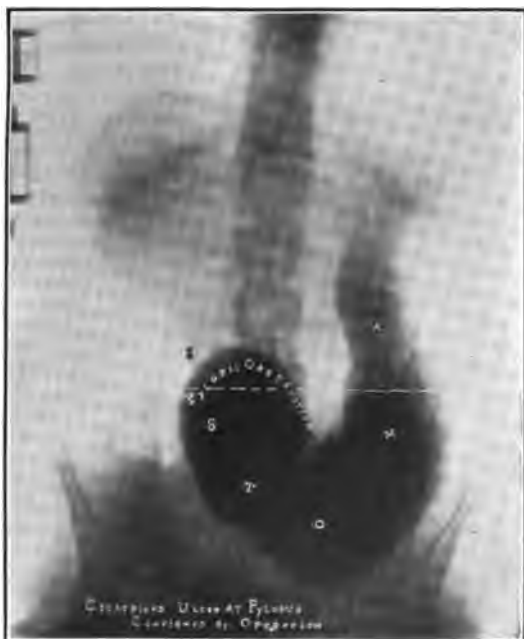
CICATRIZED ULCER AT THE PYLORUS. Female aged 35. Marked stenosis so that traces of the opaque meal remained in the stomach for 48 hours. Roentgen diagnosis confirmed at operation by Dr. J. M. Draper.
